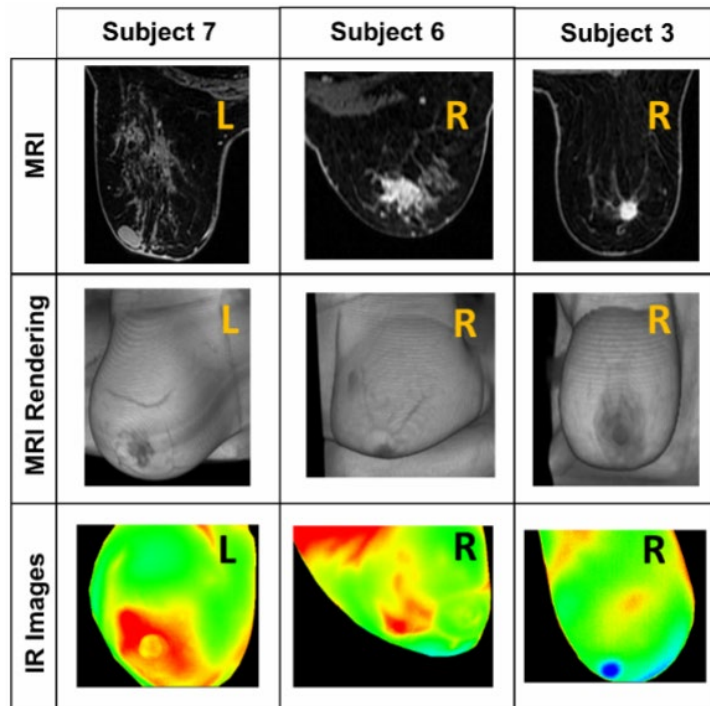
MRI, renderization from MRI, and IRI images for three subjects [126].
